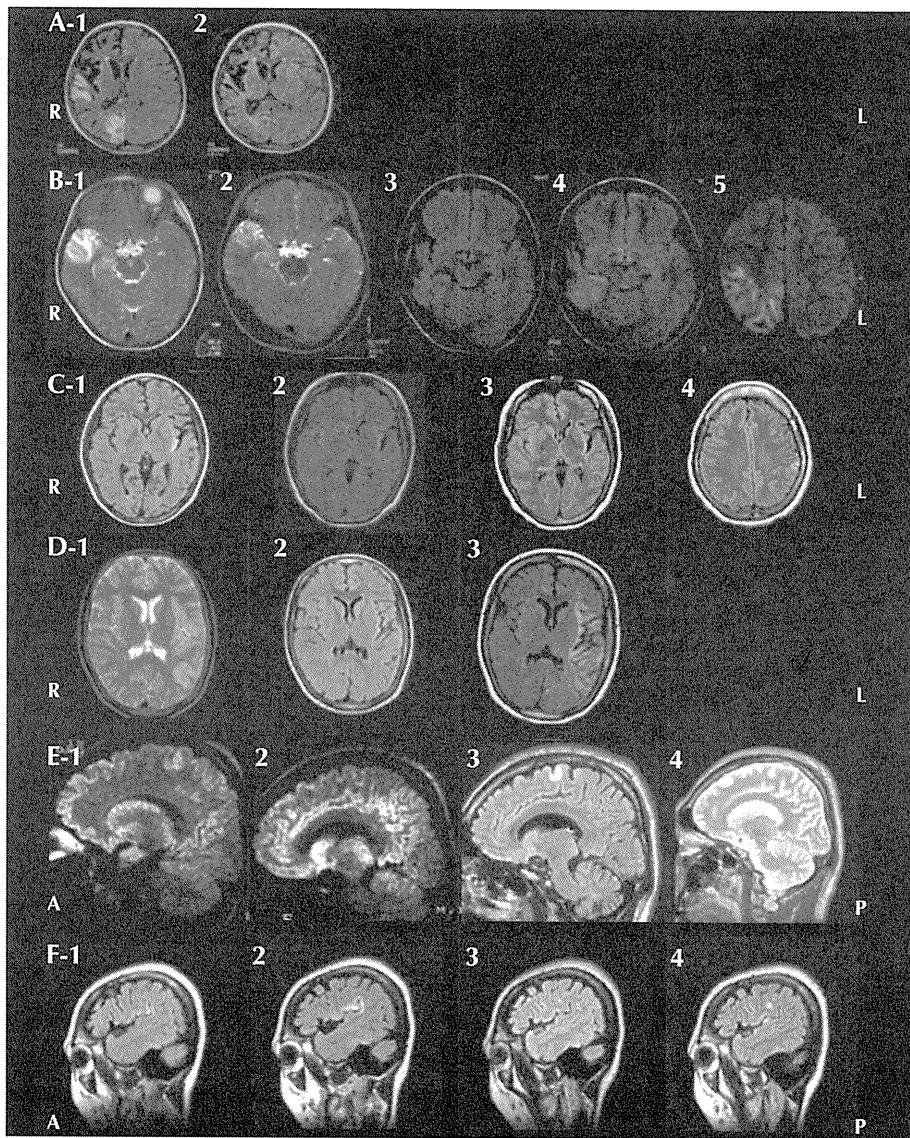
Evolutionary changes in MRI lesions.
